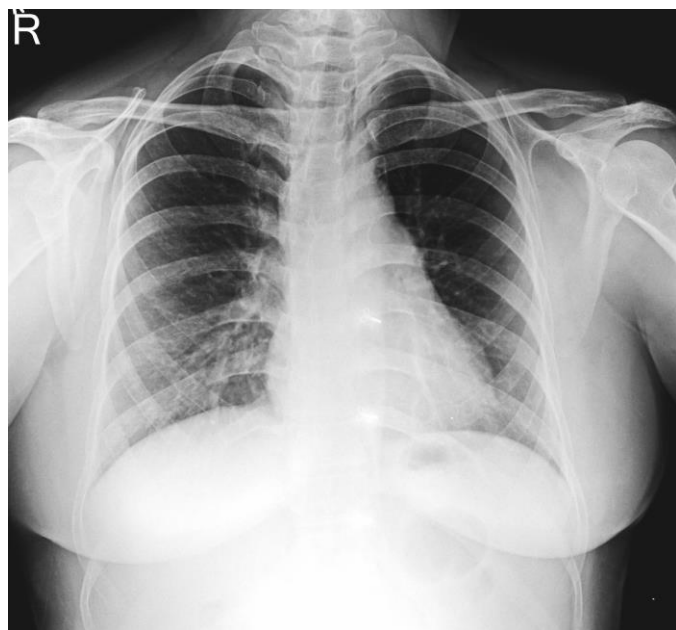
43-year-old female patient with Hajdu-Cheney syndrome. Posteroanterior radiograph of chest does not show any obvious abnormality.
